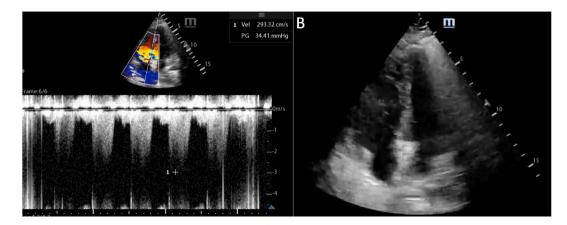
Initial Transthoratic echocardiogram obtained with the patient in prone position. A) 4 Chambers view showing the Tricuspid regurgitation of 2.9 m/seg measured with CW. B) 4 chamber view showing the right ventricular dilation, systolic RV disfunction was assessed.
